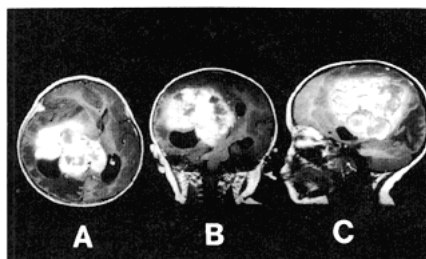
T1-weighted magnetic resonance image. *A*, gadolinium-enhanced axial view. *B*, gadolinium-enhanced coronal view. *C*, plain sagittal view. A multilobular tumor with mosaic intensity was observed, extending from the right paraventricular region to the trigon, pineal region, and subcortical white matter.
